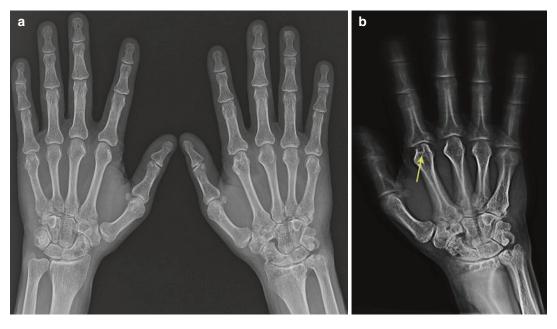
(a) Plain radiograph which looks essentially normal in a 38-year-old man with a 1-year history of arthritis symptoms; (b) corresponding tomosynthesis
